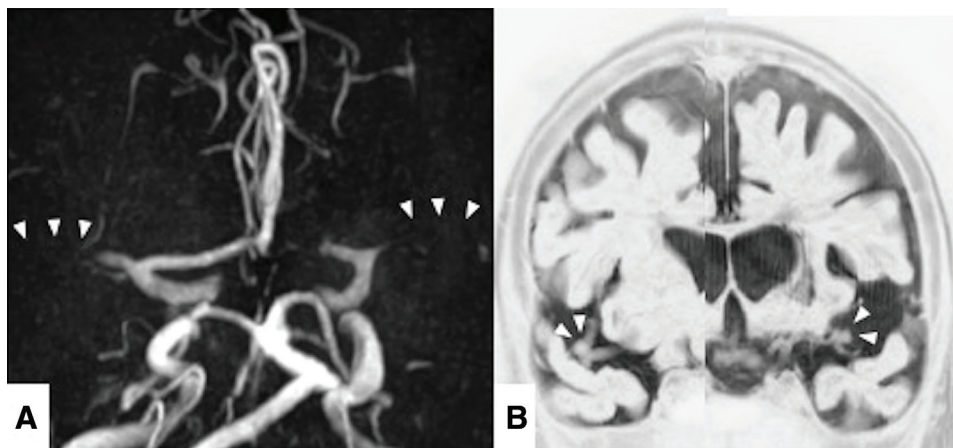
An 84-year-old woman with consciousness disturbance. (A) MRA shows occlusions on both sides of the MCA, as indicated by arrowheads. (B) Bifurcation aneurysms on both sides of the MCA can be seen on MAS-MRI. The arrowheads indicate aneurysms. MAS: MCA anatomical scanning; MCA: middle cerebral artery; MRA: magnetic resonance angiography; MRI: magnetic resonance imaging
